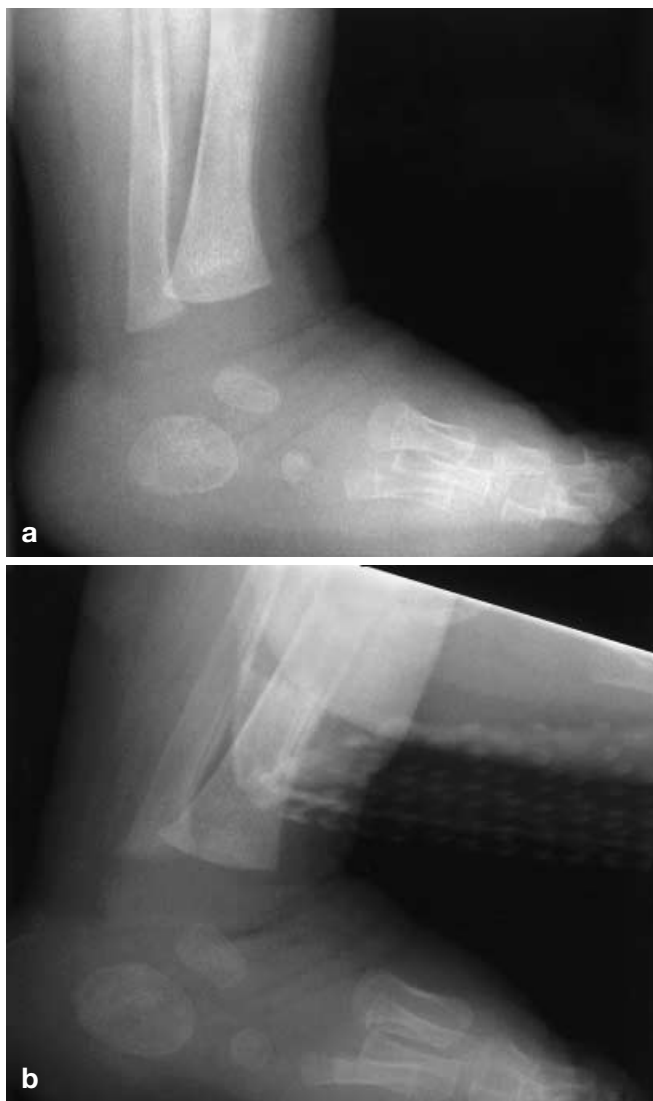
Case 6. Lateral radiograph (a) of left foot at 1.5-months of age showing minor periosteal reaction and linear sclerosis within distal tibial metaphysis. Follow-up lateral X-ray (b) 1 month later with added periosteal healing bone at tibia and fibula and resolving sclerosis
